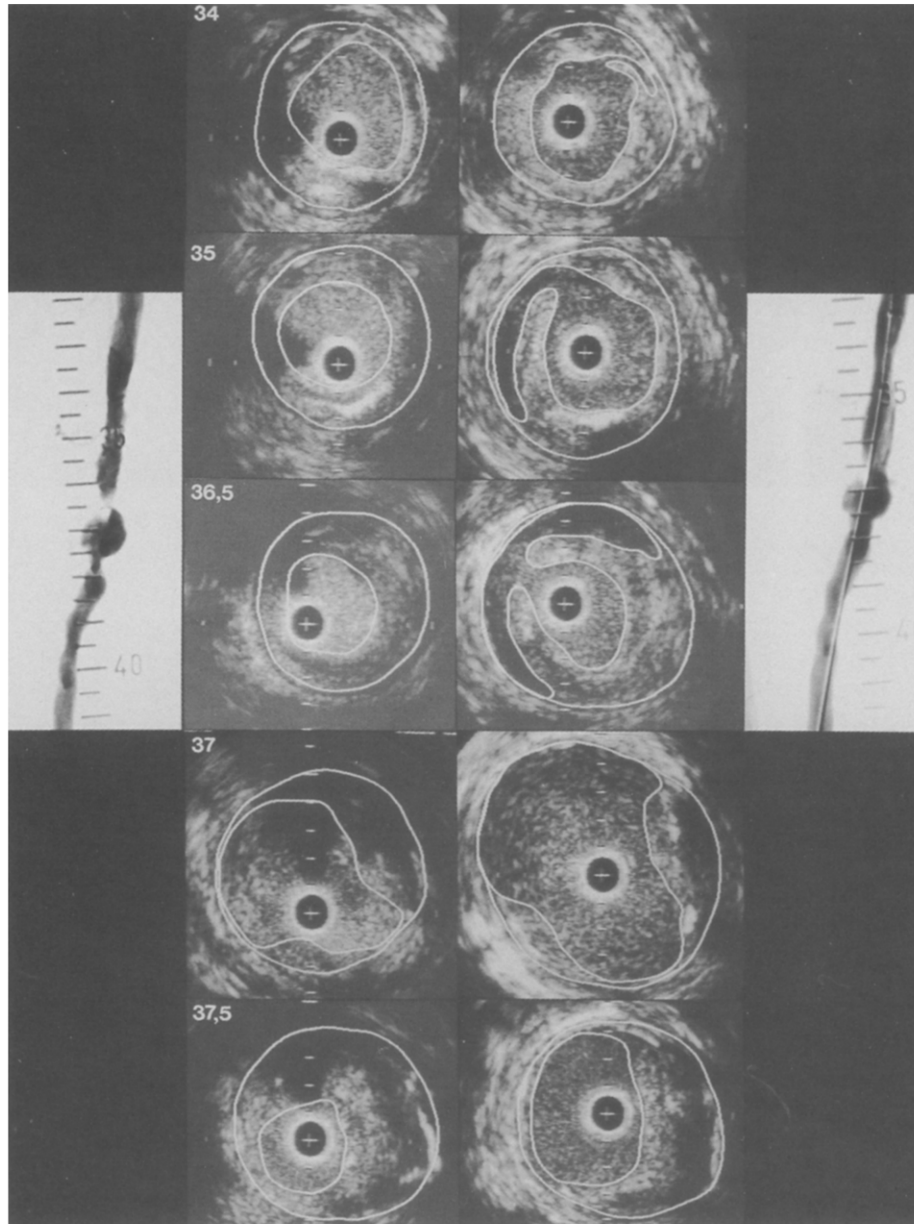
Angiograms and corresponding intravascular ultrasound (IVUS) cross-sections obtained with a 0.5 or 1 cm interval from a patient before (left) and after (right) balloon angioplasty of the superficial femoral artery. The IVUS cross-sections are contour traced off-line facilitating the recognition of free lumen area (inner contour) and media-bounded area (outer contour). Note the variety in morphological features seen on IVUS before and after PTA. Dissections were seen at levels 34–36.5 cm. Catheter = +; calibration = 1 mm.
